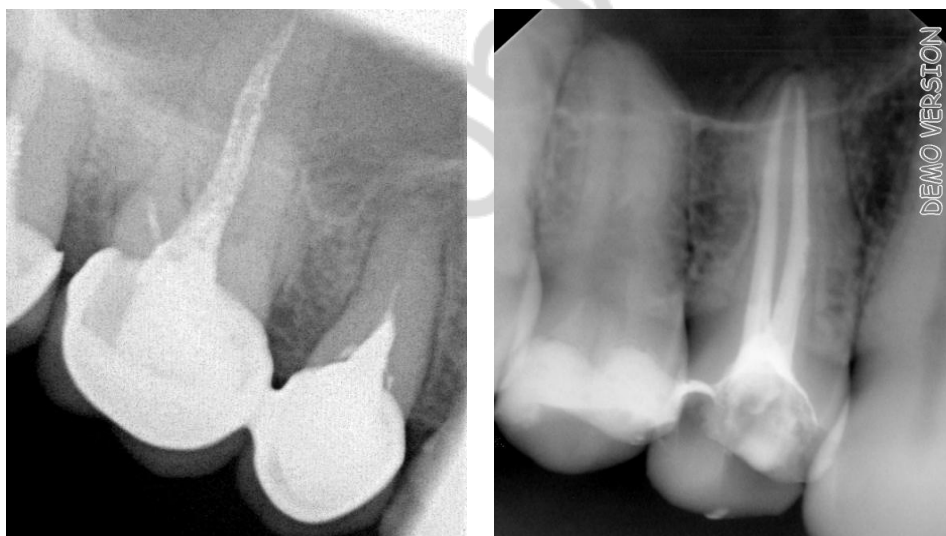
Dubious (on the left) and suitable (on the right) X-ray criteria of endodontic treatment
